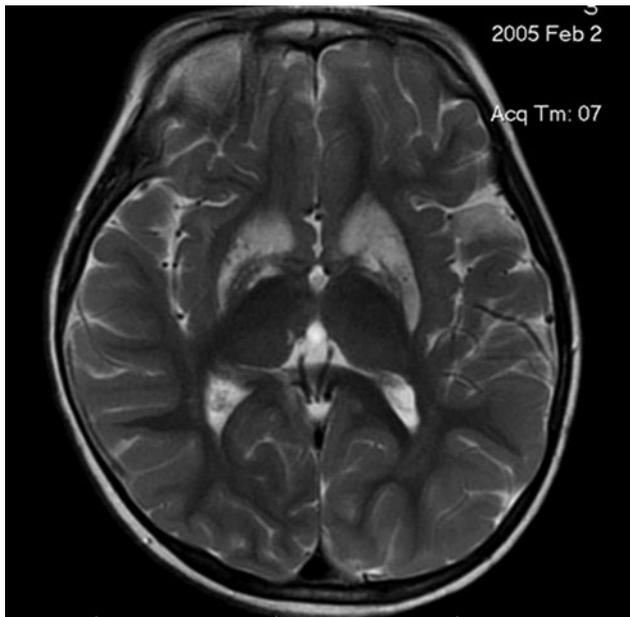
Axial magnetic resonance image demonstrating caudate and putaminal changes associated with generalized secondary dystonia.
